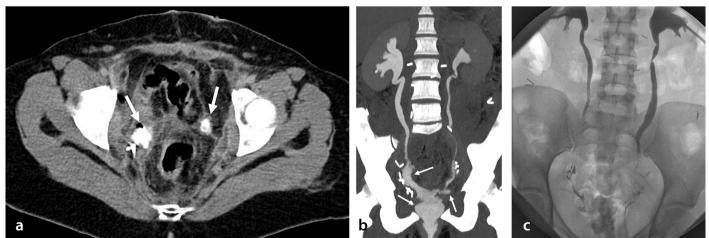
A 40-year-old woman presented with a vaginal urine leak following hysterectomy. CT urography demonstrated distal ureteral contrast extravasation and ureterovaginal fistula (arrows, a and b). Bilateral nephrostomy was performed (c). The patient underwent bilateral ureteroneocystostomy due to failure of ureteral stent placement. CT, computed tomography.
